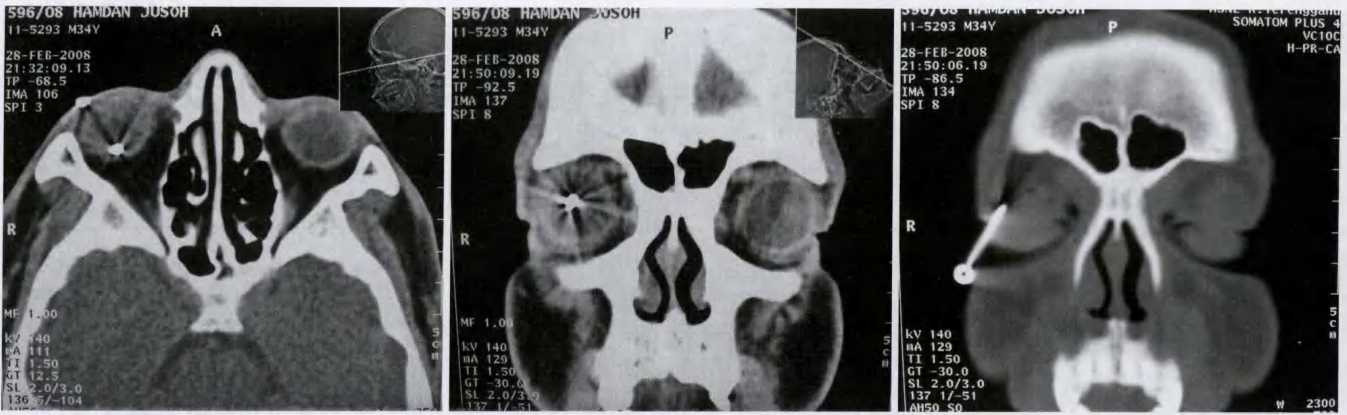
CT-scan orbit shows a highly dense foreign body within the right globe and part of the foreign body is embedded at the posterior part of the sclera
